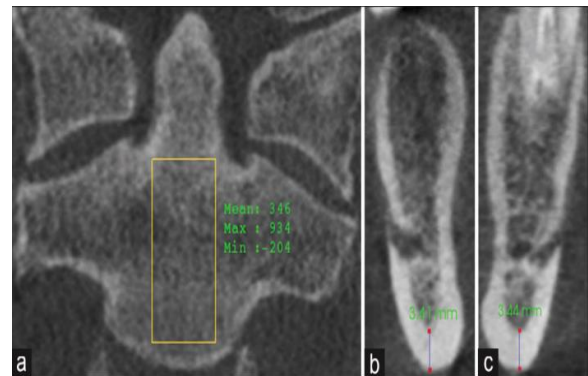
CBCT scan of a patient at low risk of osteoporosis; (a) C2 density; (b) MI at the right side of the mandible; (c) MI at the left side of the mandible
